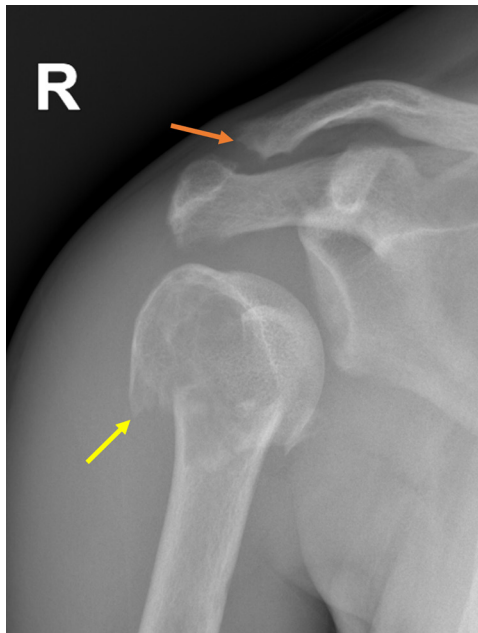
Shoulder radiograph demonstrates a central lytic lesion in the proximal humerus with a pathological fracture (yellow arrow). There is a narrow zone of transition, with no periosteal reaction or evident soft-tissue mass, features favouring a benign, non-aggressive process. Bone resorption of the acromioclavicular joint surfaces is also present (orange arrow).
